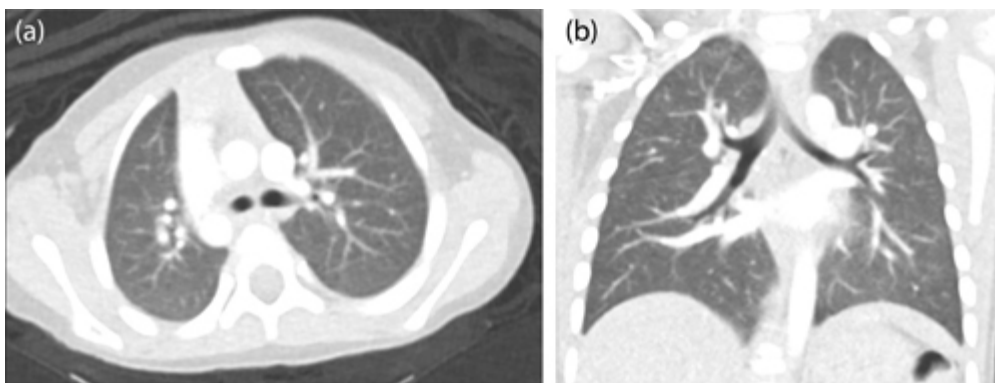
(a) CT thorax showing interval resolution of the right paratracheal lymphadenopathy with normal calibre of bilateral main bronchi. (b) CT thorax showing normal calibre of bilateral main bronchi and bronchus intermedius. [↩](#)
